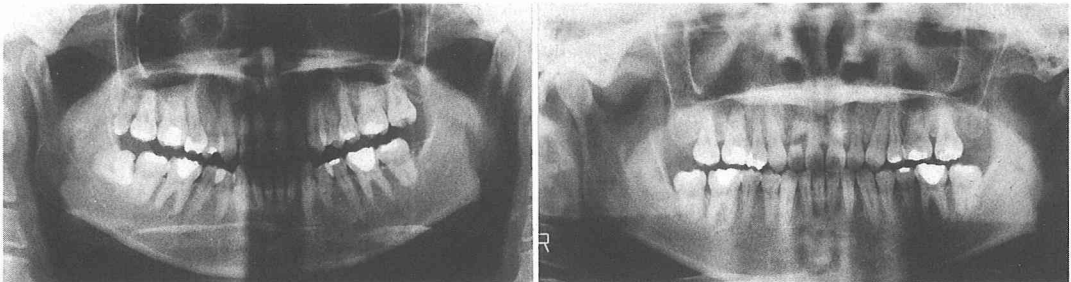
Panoramic radiographs. Pre-treatment (Left) and post-treatment (Right).
